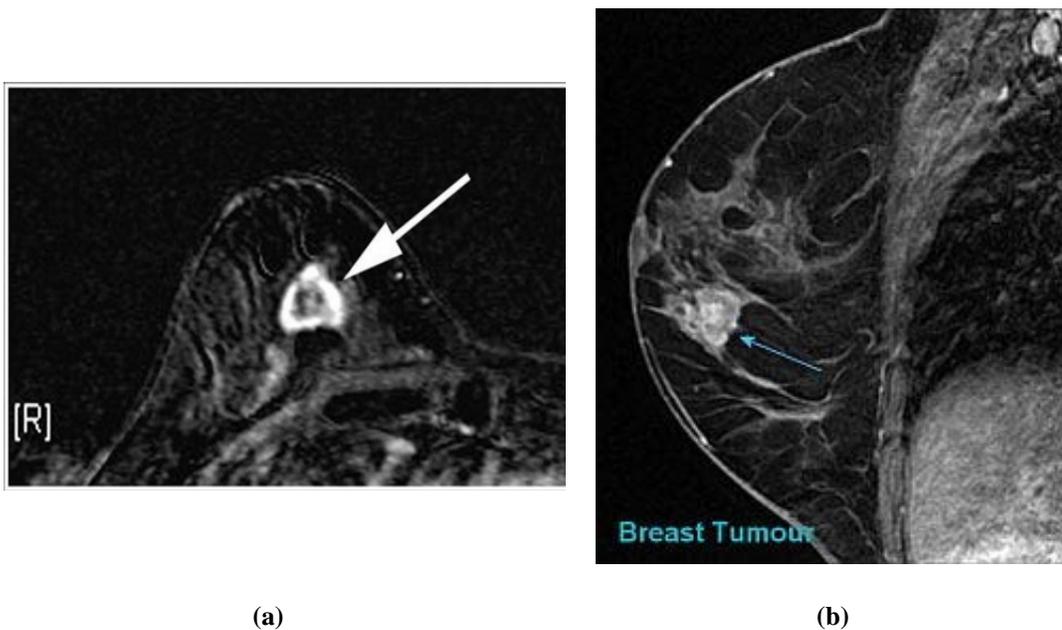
A typical breast tissue image using Magnetic Resonance Imaging (MRI) technique in two different positions.
